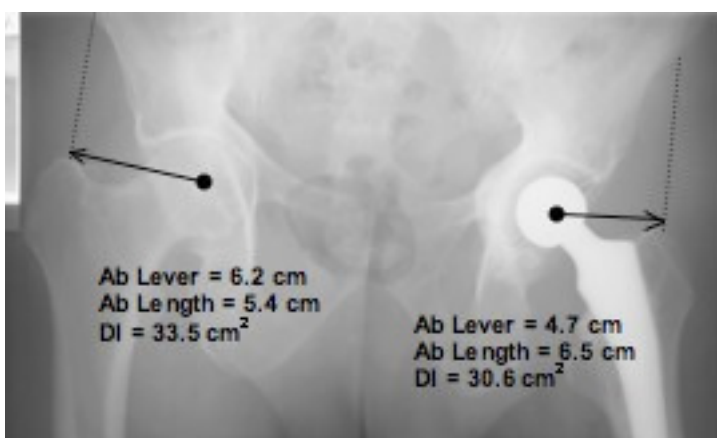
Example of a postoperative pelvic radiograph (from patient nº 5) presenting notorious differences in abductor muscles (Ab) geometric parameters and in the resulting Dysfunction Index (DI) between operated and non-operated hip joints
